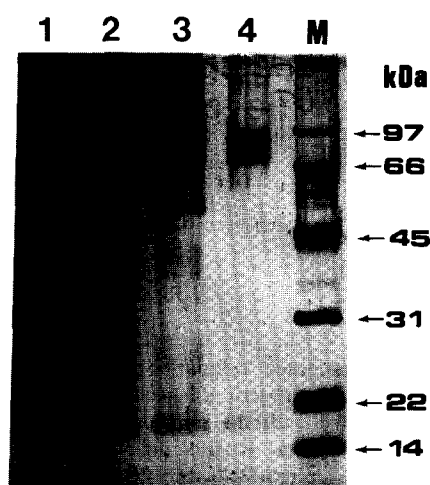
SDS-PAGE (10% polyacrylamide) of *H. pylori* cytotoxin. Lane 1, proteins precipitated from a broth culture supernatant of CT-positive *H. pylori* with a 50% saturated solution of ammonium sulfate; lane 2, CT purified by IEF chromatography; lane 3, CT purified partially by cation exchanger; lane 4, a major band indicating purified $M_r = 87000$ toxin after gel filtration HPLC. Chromatography conditions were as described in the text. Lane M, a low molecular weight marker protein. Each lane contains 0.05 units of CT in the purified fraction.
